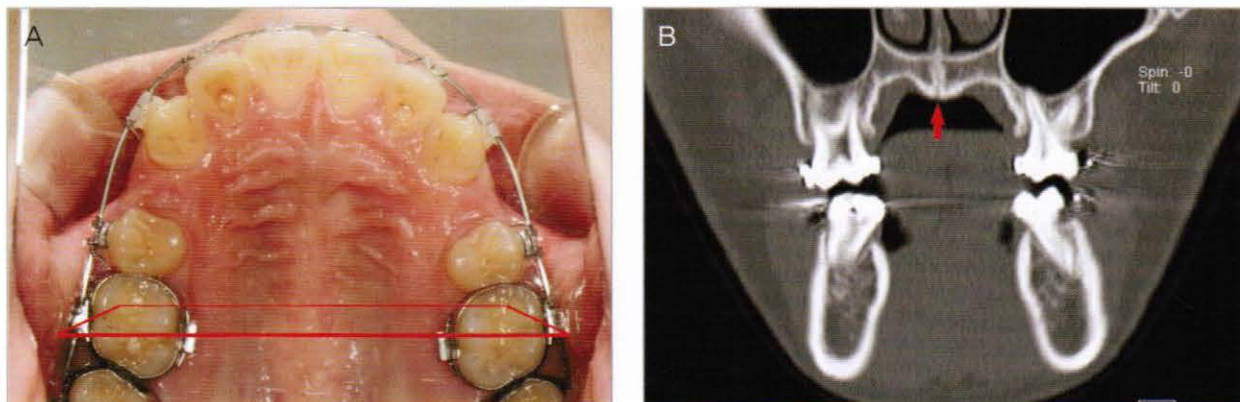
CT of upper first molar area
